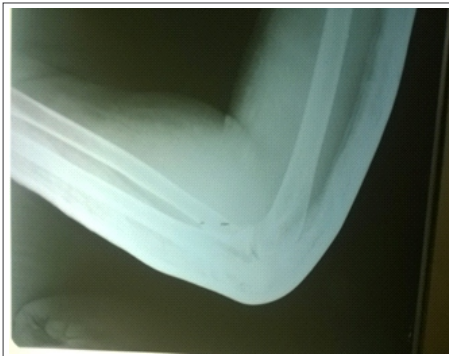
Post-reduction X-ray of right elbow showing well reduced dislocation
